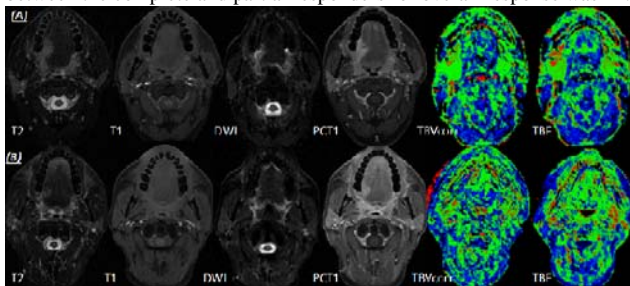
T2, T1, DWI, Post-contrast T1, TBVcorrected map, TBF map of a patient with Ca tongue; (A) before radiotherapy, (B) after radiotherapy
